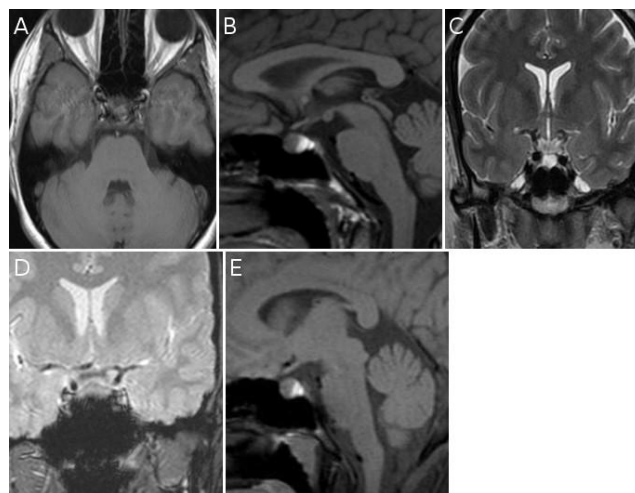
The first examination, magnetic resonance images of a patient presented: The lesion is isointense with hyperintensity on T1 - weighted images axial (A) and sagittal (B), hyperintensity in T1 weighted- Fat suppression (E) and T2 - weighted image (C), while heterogeneous signal intensity on T2*weighted image (D)
